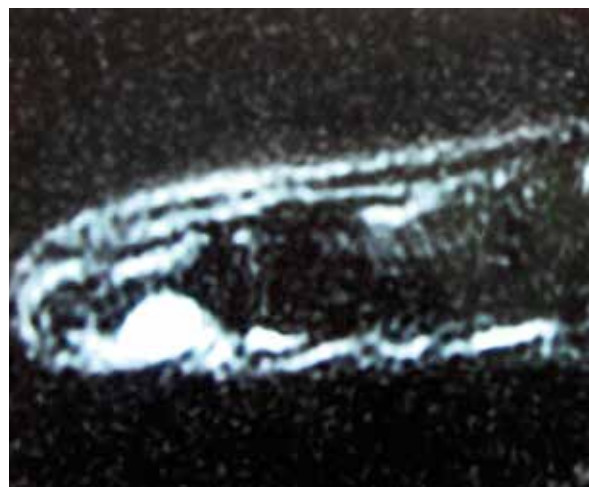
MRI of glomus tumor (a sagittal view)
